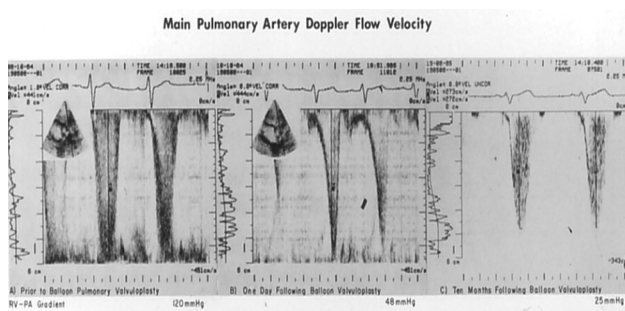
Doppler studies conducted before balloon pulmonary valvuloplasty (BPV) (left panel), the day after BPV (middle panel, corresponding to Figure 10A), and at the 10-month follow-up study (right panel, corresponding to Figure 10B). Note the triangular-shaped Doppler signal in the middle panel, suggesting infundibular obstruction, which disappeared on follow-up (right panel). Reproduced from Thapar and Rao.⁵⁰
